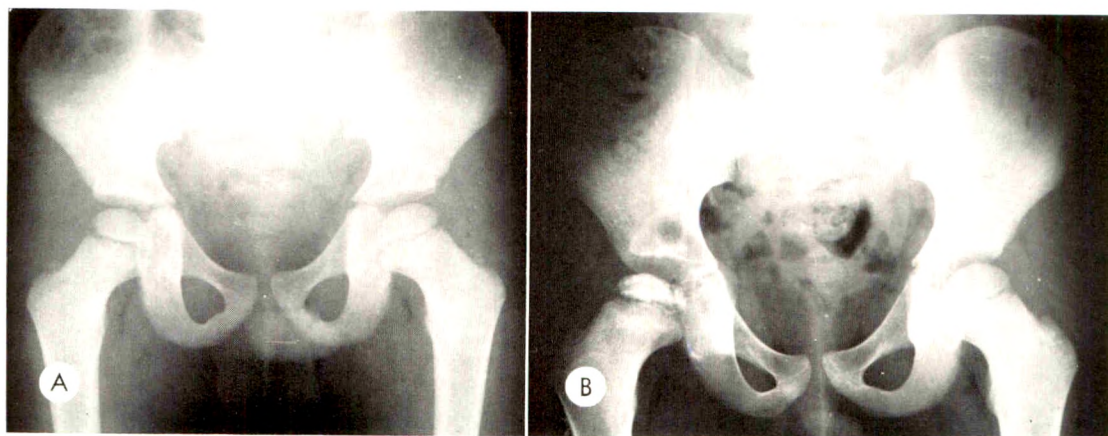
(A) Roentgenogram of pelvis read as normal without the knowledge of symptoms—pain in the hip and limp. (B) A year later, the changes of Legg-Perthes disease were apparent. Had the clinical findings been known originally, the long delay before diagnosis might have been avoided.
